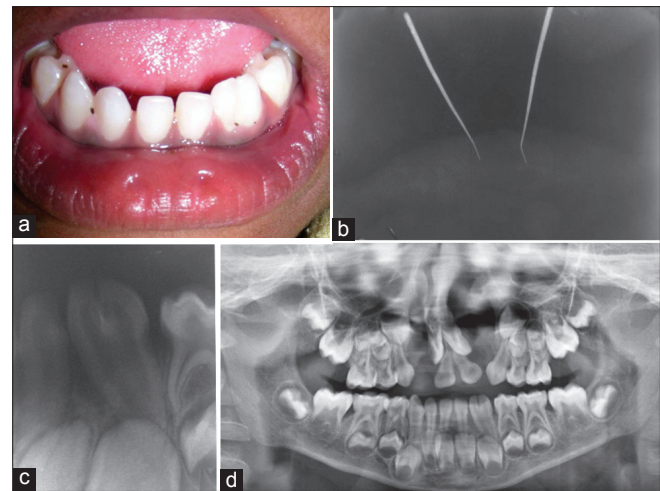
(a) Photograph showing labial pits and fusion, (b) radiograph of lower buccal pits by placing gutta-percha, (c) IOPA showing fusion, OPG showing missing maxillary bilateral deciduous and permanent lateral incisors and mandibular left permanent lateral incisor, (d) cleft alveolus and palate, and fusion
